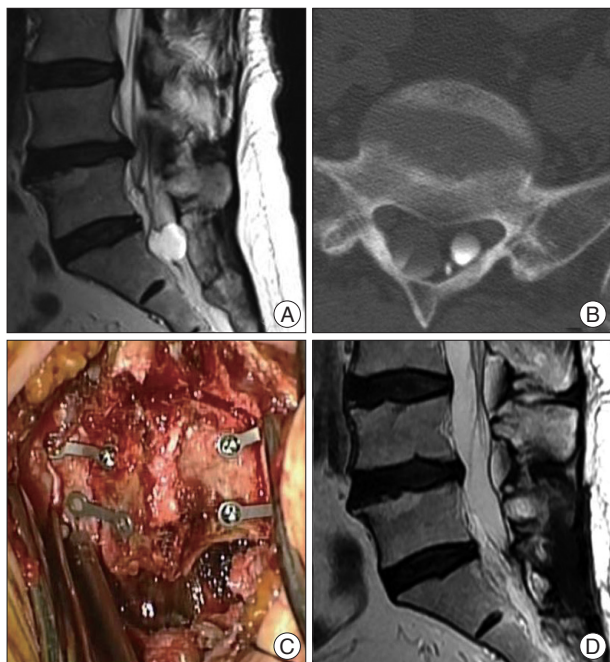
Preoperative magnetic resonance (MR) T2-weighted image sagittal image (A) showing sacral cyst. Myelogram oblique view (B) and CT-myelogram (C) demonstrates that the cyst is divided into two segments and caused compression of adjacent nerve roots. Intraoperative photograph (D) shows that the large cyst below S1 nerve root is connected with small cyst through small stalk overlying S2 root. Photograph (E) after sacral recapping. Postoperative MR T2-weighted image sagittal image (F) obtained 6 months after surgery demonstrates complete excision of cyst.
